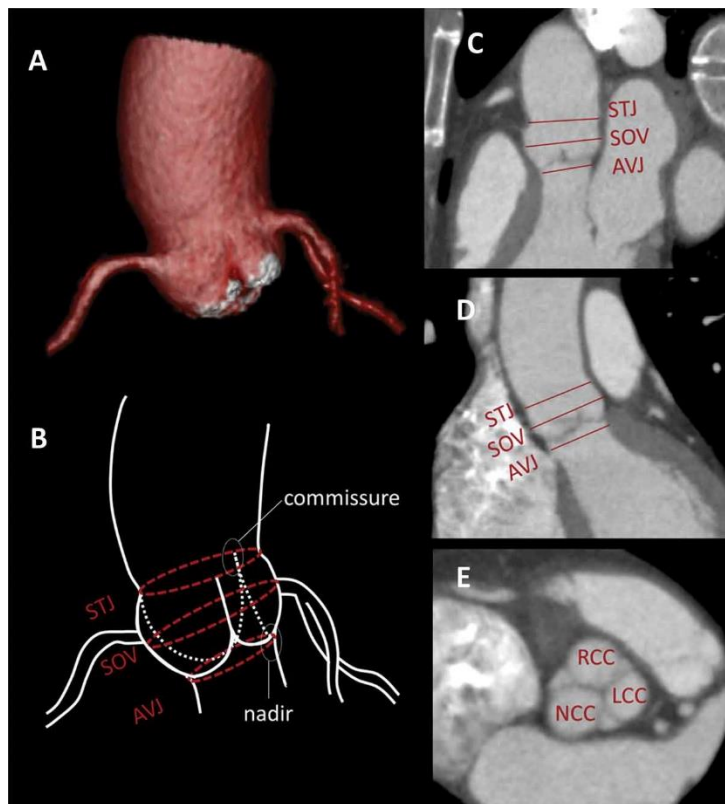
Anatomy of the aortic valve and root visualized with multi-detector row computed tomography. Panel A shows the 3D volume of the aortic root. Panel B reconstructs the aortic root with the demarcation of the different components: aortoventricular junction (AVJ), sinus of Valsalva (SOV) and sinotubular junction (STJ), commissures and nadirs of the aortic valve. Panels C, D and E show the sagittal, coronal and double oblique view of the aortic root and aortic valve, respectively.
